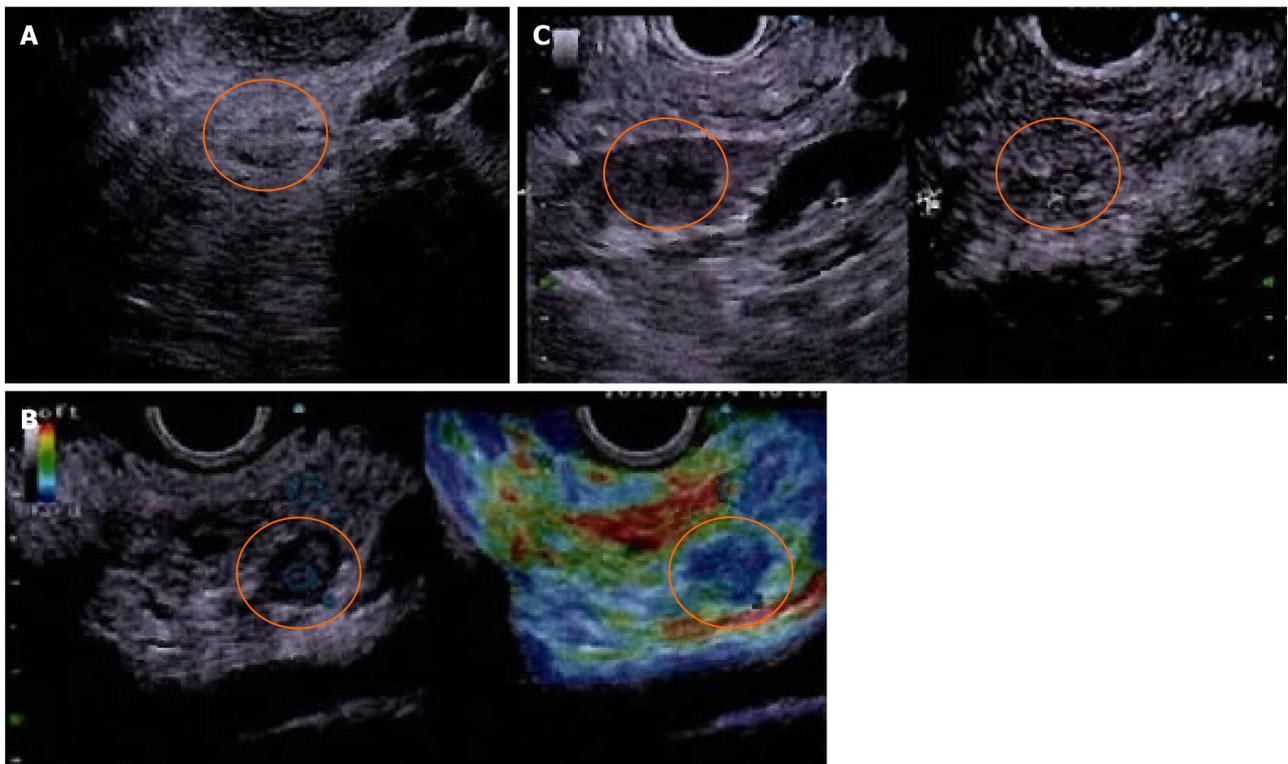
Endoscopic ultrasound images. A: The tumor showed a 14 mm solid and low echoic mass in the pancreatic body (orange circle); B: Endoscopic ultrasound (EUS) elastography showed a strain ratio < 0.05 (orange circle, right image: Elastography image); C: Contrast enhanced EUS showed short term contrast effects in the early phase and washed out quickly (orange circle, right image: Sonazoid mode of delay phase).
